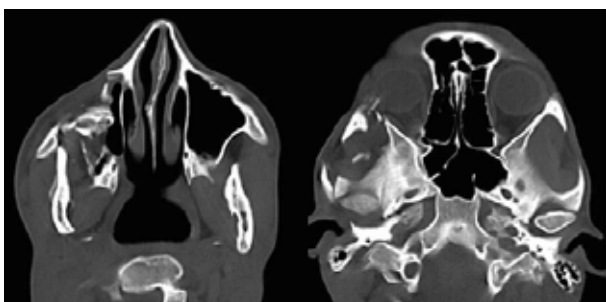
Preoperative CT scan. Case 1.
